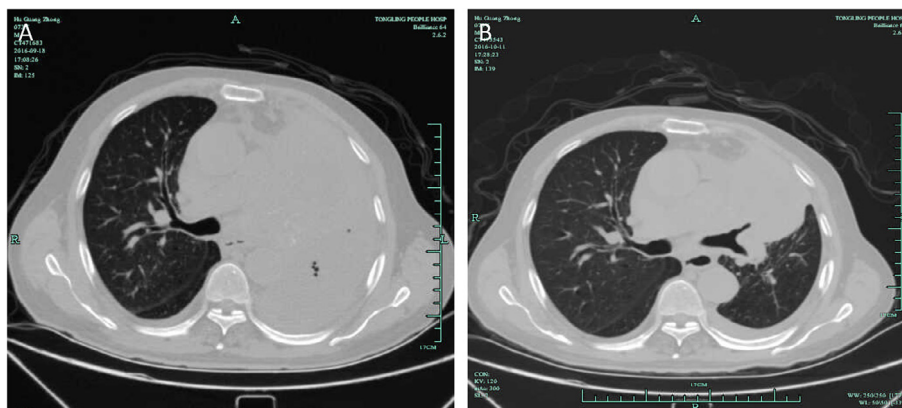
Patient 3: Computed tomography showed primary tumor the right lung (A) before and (B) two weeks after apatinib treatment.
